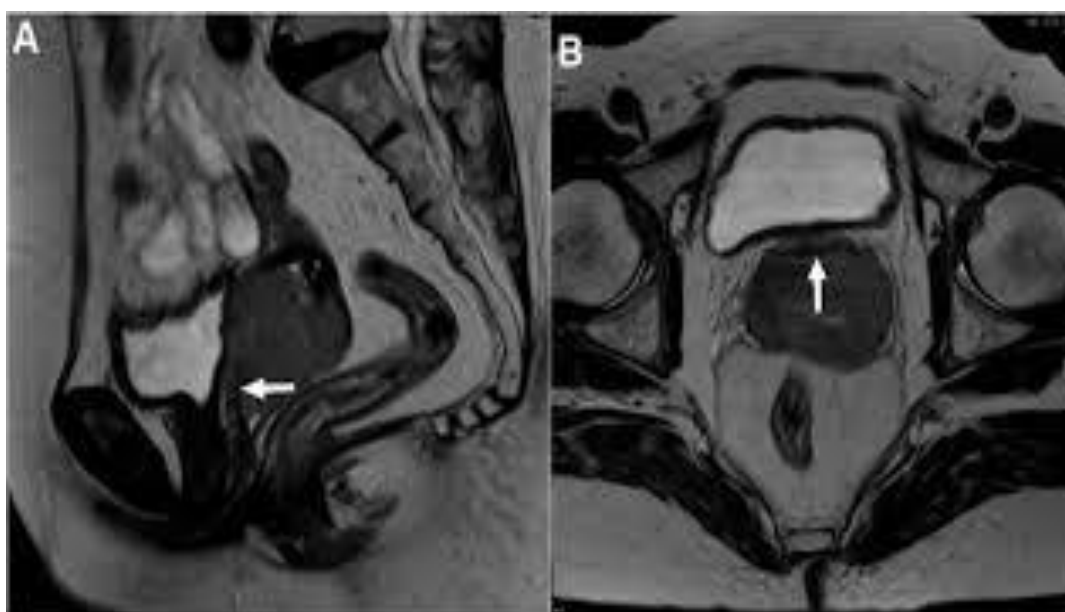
MRI finding of FIGO Stage IIIB squamous cell carcinoma of the cervix.
